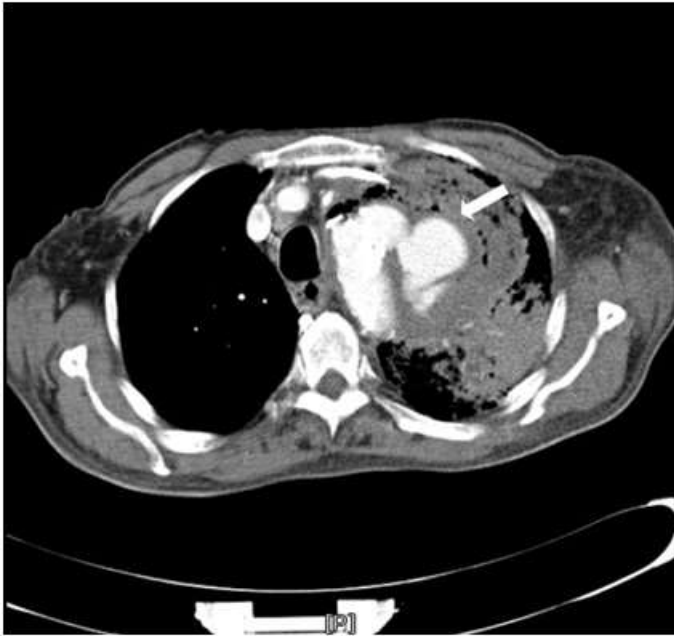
Computed tomography (CT) of chest performed 2 days after admission demonstrated one ruptured thoracic aortic aneurysm (arrow).
